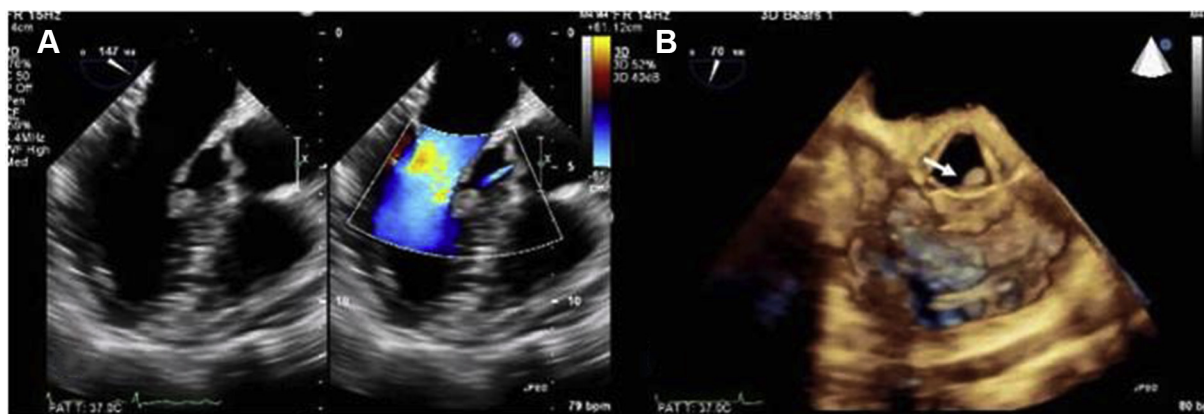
(A) Mid-esophageal long-axis view at 147° shows a rounded mass (1 cm × 0.8 cm) attached to the basal interventricular septum approximately 1 cm away from the aortic valve (white arrow). There is trace to mild aortic regurgitation not related to the mass. (B) Preoperative 3D transesophageal picture at 70° shows the aortic valve in systole seen from aortic prospective; during this systolic frame, the mass is clearly seen (white arrow) below the aortic valve. In real time, the motion of the mass is well appreciated.
